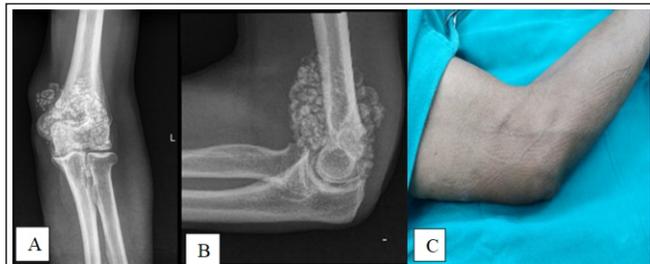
A & B- Preoperative radiograph showing multiple stippled calcifications; C- Showing preoperative range of motion of elbow
